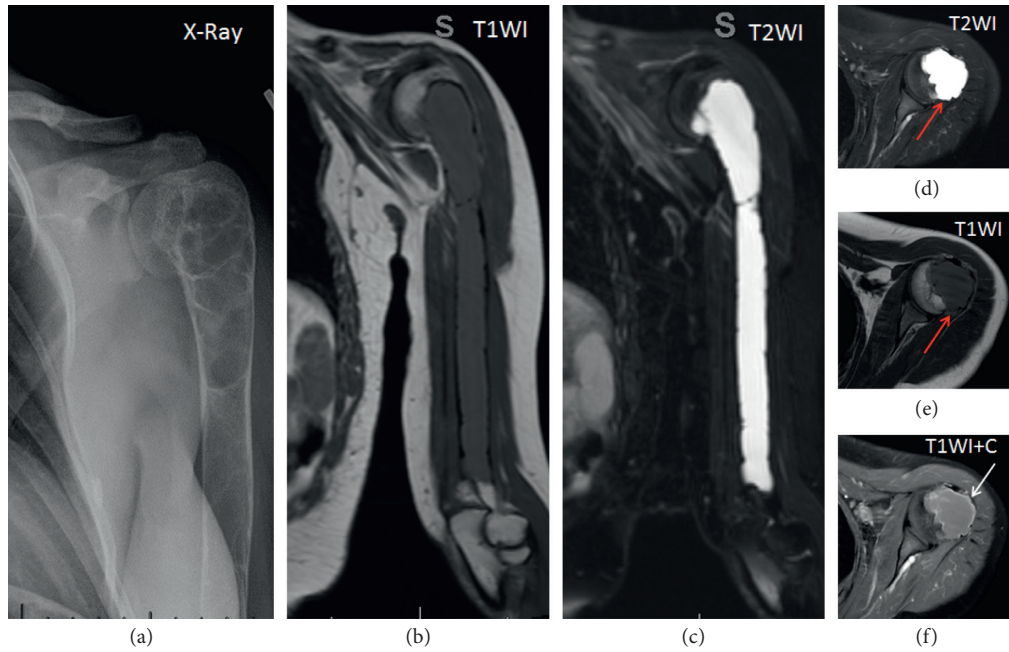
Left humerus brown tumor. X-Ray shows a large, well defined, multiloculated soap-bubbly lucent lesion. MRI T1WI the lesion is similar to the muscle, on coronal and axial T2WI the lesion is hyperintense (very bright), axial T1WI without contrast the lesion is hypointense with prominent thinning of the cortical bone and minimal extension beyond the cortex (red arrows), axial T1WI + C with contrast and fat saturation shows diffuse and peripheral enhancement (white arrow).
